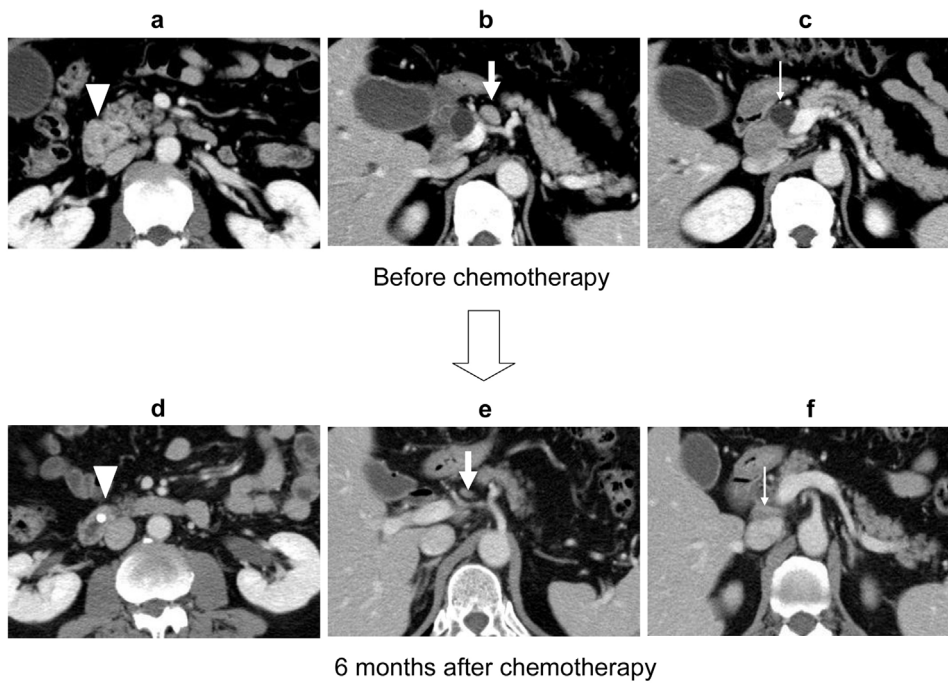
CT scans show reduction of tumor (arrow heads) in the ampulla Vater (a,d), lymphnodes #8a (arrows) (b,e) and #12b (thick arrows) (c,f).
